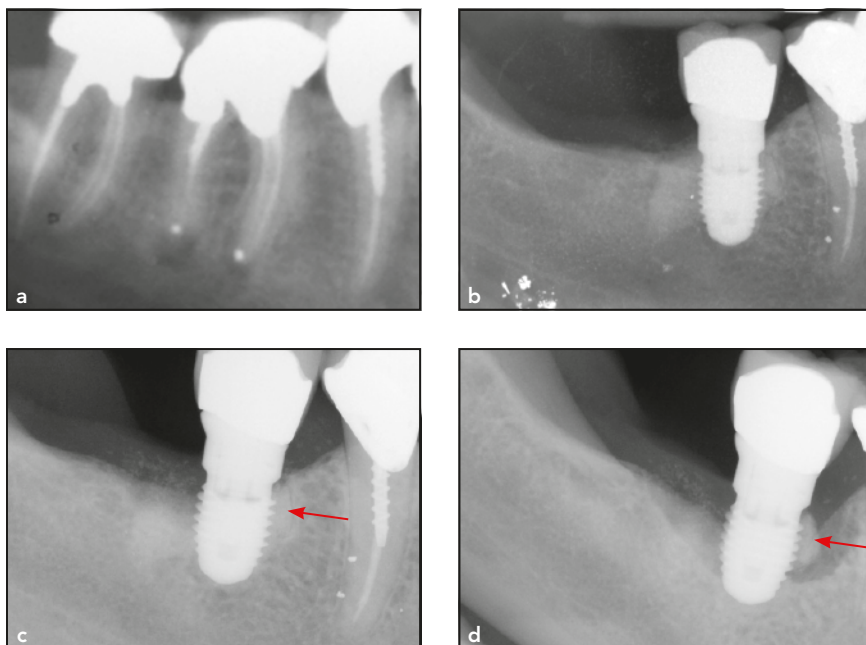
Mandibular first molar treated in 1991 with endodontic therapy and in 1998 with apical endodontic surgery. (a) Section of 1999 panoramic radiograph. (b) Dental implant-supported restoration replacing mandibular right first molar with healthy bony profile at 4 years after implant loading in 2007. (c) Periapical radiograph at 9-year follow-up. Note the opaque fragment on the mesial side of the implant (arrow). (d) Radiograph taken in 2014 reveals failing implant almost 11 years postloading and evidences a retained root fragment attached to the mesial surface of the implant (arrow).
